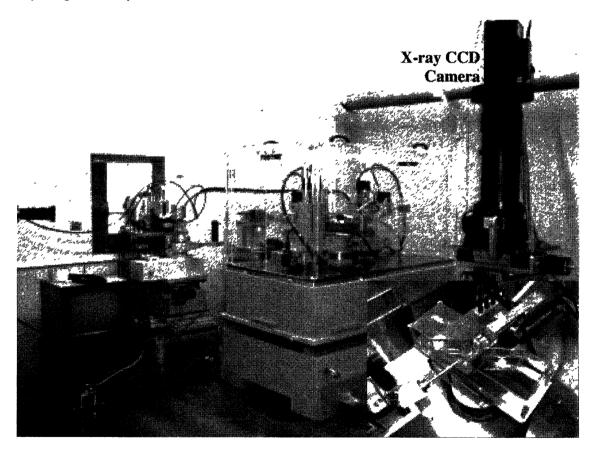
A picture of phase-contrast X-ray imaging system with a monolithic x-ray interferometer Inset Set up of CT object
